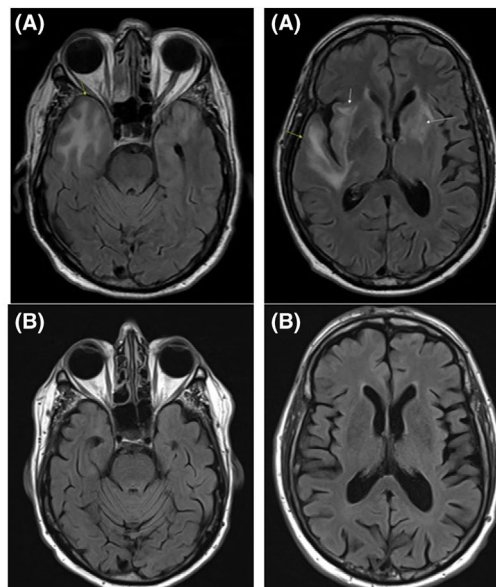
Brain magnetic resonance imaging (MRI) example.
